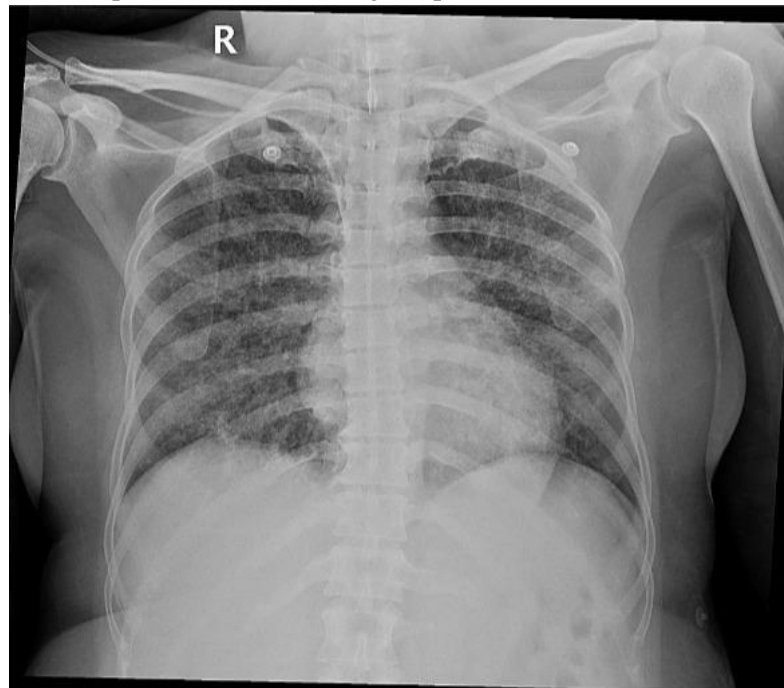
Chest X-ray examination showed bilateral pneumonia.
